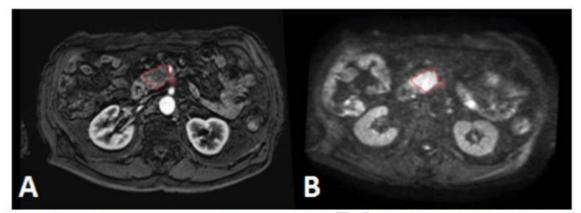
Unresectable pancreas case with contouring of tumor on arterial T1-weighted image (A) and on DWI (B). Red line: GTV. Note the hypointense area on the T1-weighted image and the diffusion restriction on the DWI.
